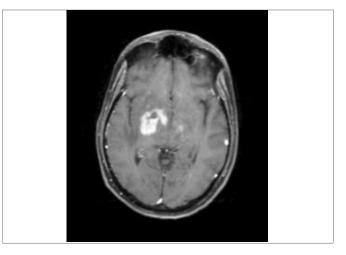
MRI brain with contrast showing large right basal ganglia lesion.
